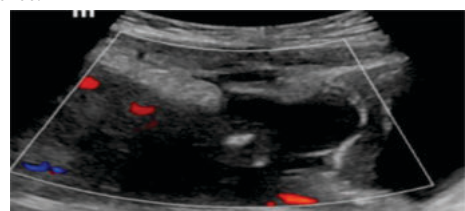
A transabdominal ultrasound scan (TAS) of the uterus shows a
